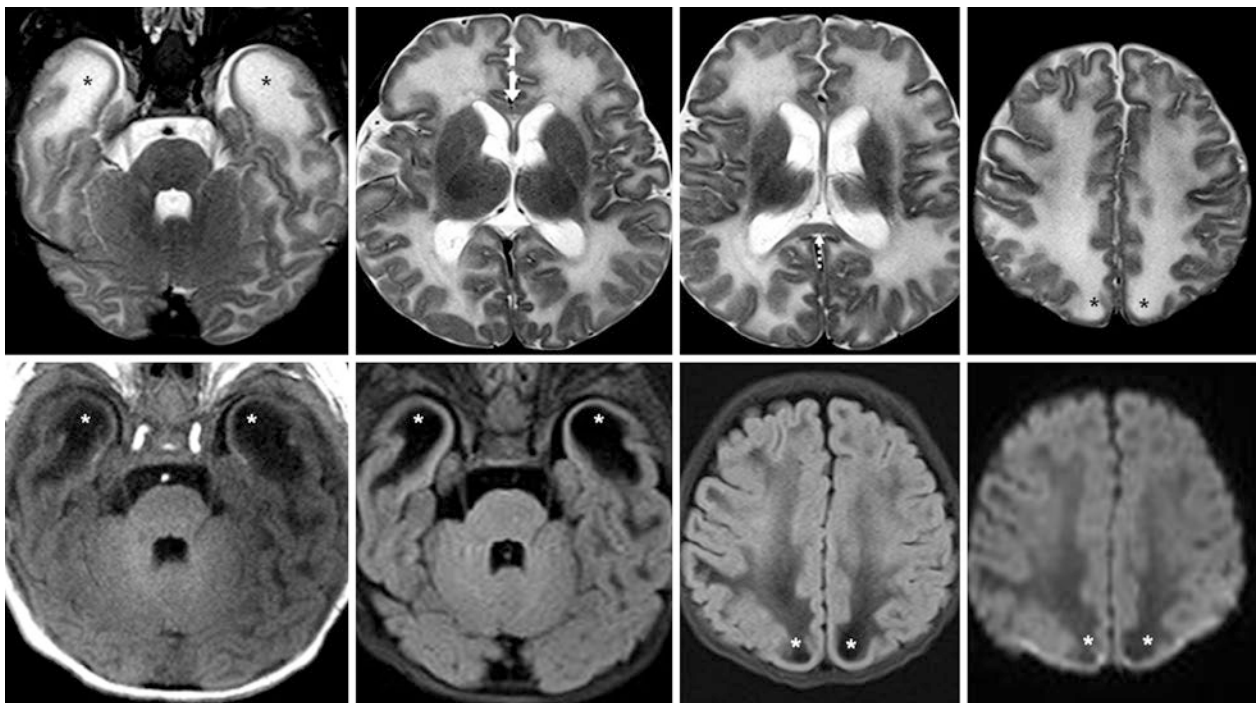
Comparison case of megacephalic leukoencephalopathy with subcortical cysts (van der Knaap disease). A 14-week-old with motor delay had a 3T MRI with SE T2WIs (*top row*). Note the quite T2-bright edema that has been called “cysts” within the anterior temporal and high parietal lobes (*asterisks*), which are dark on both T1WI
